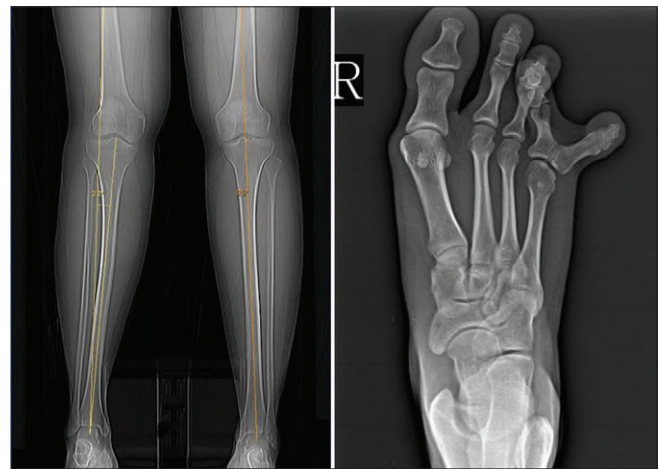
X-rays showing the valgus alignment of the lower limbs and deformity of the fourth and fifth toes. (Reproduced from Kambhampati SBS^[4])
